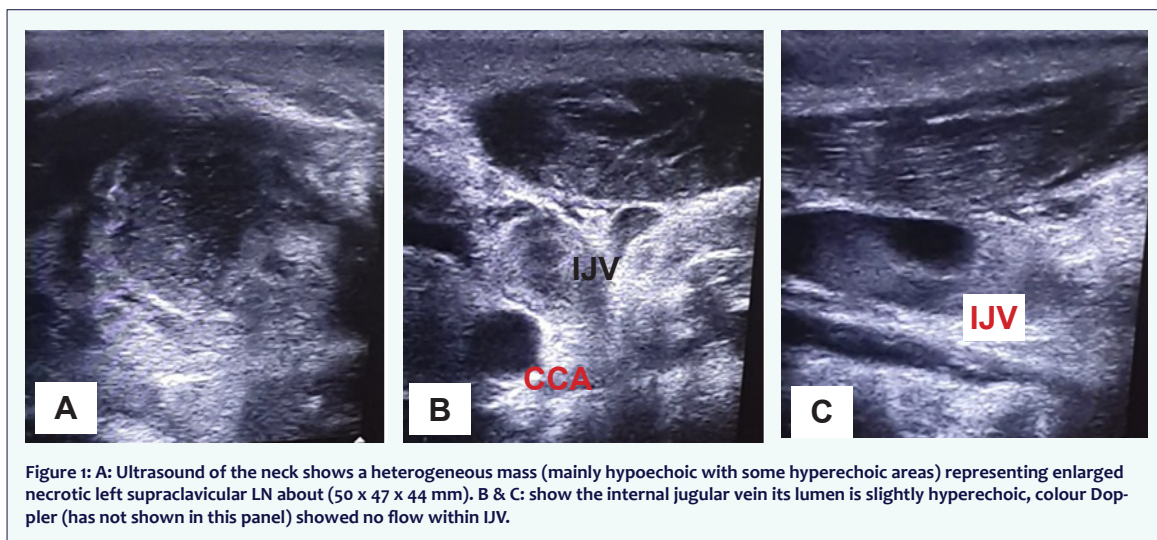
A: Ultrasound of the neck shows a heterogeneous mass (mainly hypoechoic with some hyperechoic areas) representing enlarged necrotic left supraclavicular LN about (50 x 47 x 44 mm). B & C: show the internal jugular vein its lumen is slightly hyperechoic, colour Doppler (has not shown in this panel) showed no flow within IJV.
